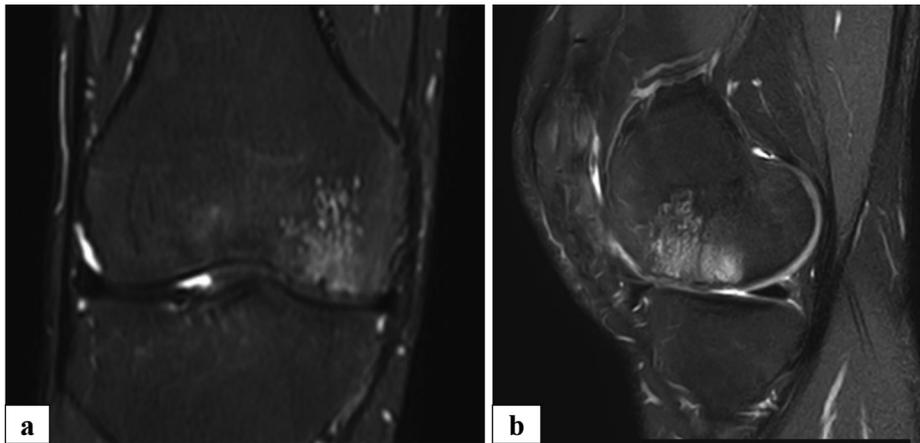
Gel-based ACI for right knee lateral femoral condyle ICRS grade IV single chondral defect measuring  $5.5 \times 1.5$  cm ( $8.25$  cm<sup>2</sup>). (a)(b) MRI delineates the unstable osteochondral lesion of the lateral femoral condyle secondary to avascular necrosis. (c) Recipient site preparation. (d) Gel-based ACI implantation. (e)(f) Post-operative MRI 6 months post-ACI reveals a stable cartilage repair. (g)(h) Post-operative MRI 24 months post-ACI reveals complete defect filling with homogeneous repair and an intact smooth surface. (i) Relook arthroscopy 1 year post-ACI reveals an ICRS grade II (nearly normal) cartilage repair with repair in level with surrounding cartilage, with a demarcating border  $< 1$  mm., and intact smooth surface.
